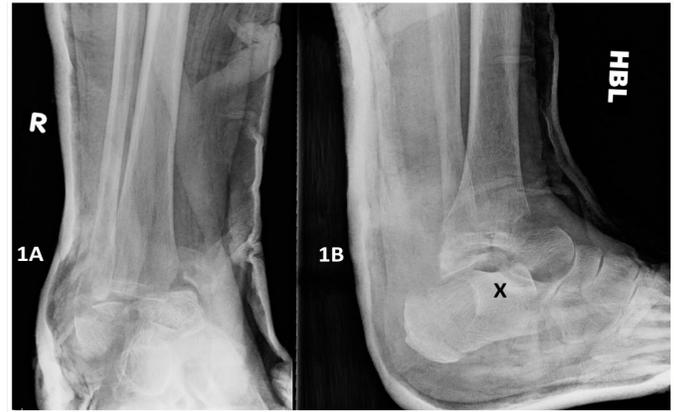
Preoperative radiographs lateral and AP views.
